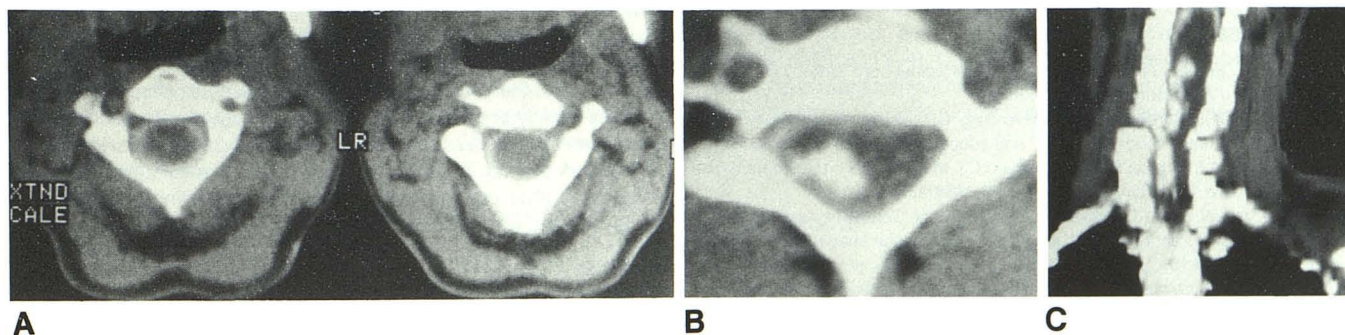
Contrast-enhanced CT scans of cystic intramedullary oligodendroglioma.
